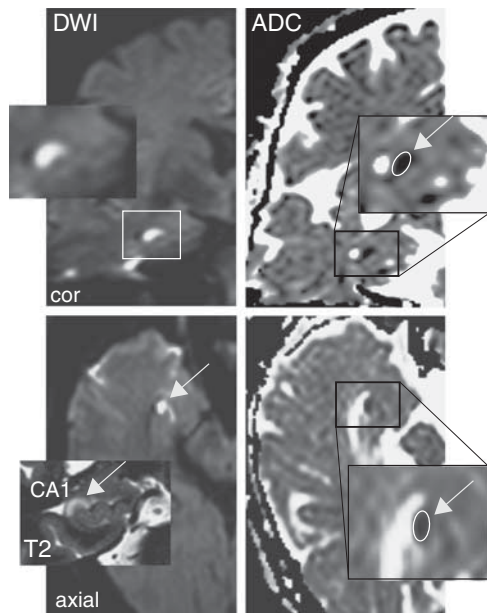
Analysis of diffusion changes and apparent diffusion coefficient (ADC) in the hippocampus. The mean ADC was calculated by manually defining regions of interest (ROIs) that were positioned in the area of the hyperintense DWI lesion in CA1. Magnetic resonance images (3 T) showing a DWI lesion in the head of the right cornu ammonis in the coronal and transversal plane (upper and lower left) with a corresponding lesion in the T2-weighted image (inset, lower left). Inset (upper left) shows the magnified DWI lesion and the ADC signal changes in the coronal (upper right) and transversal plane (lower right) indicating the ROIs for quantifying the ADC values (insets upper and lower right).
